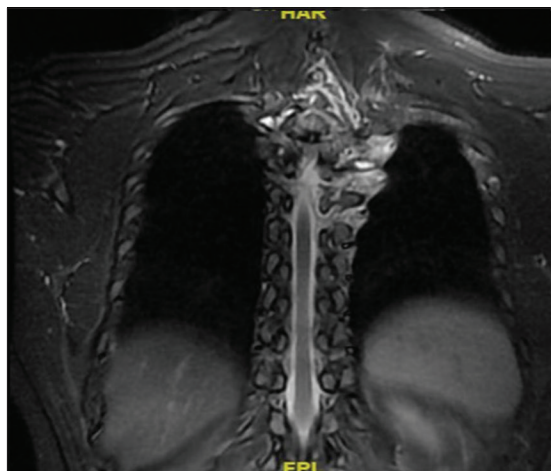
MRI dorsal spine coronal view/STIR image showing contiguous involvement of costovertebral joints at multiple levels noted on left side.
